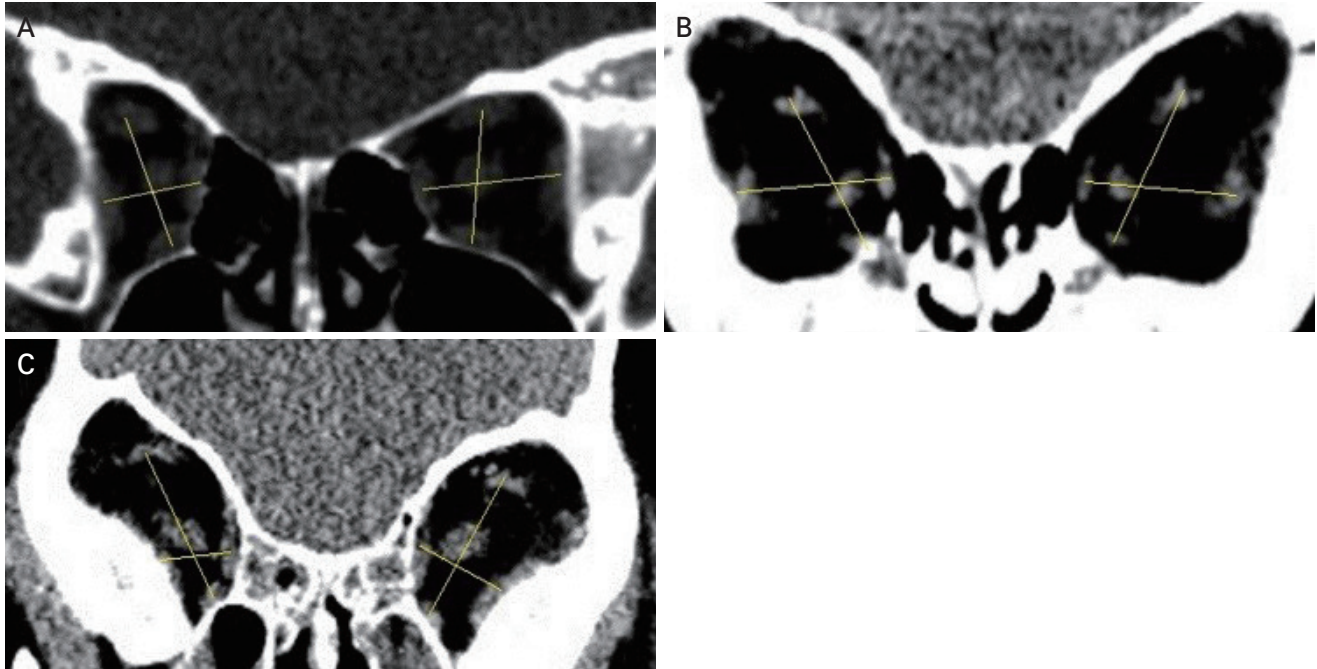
Coronal orbital computed tomography scans. (A) In mild V-pattern subjects, the orbital walls surround typically oriented four rectus muscles. (B) In moderate subjects, medial bowing of sphenoid greater wing leads to the lateral rectus down. (C) In severe V-pattern subjects, the shorter and wider orbits was accompanied by lateral displacement of the superior rectus muscles. Horizontal lines joining the center of the belly of the horizontal rectus muscles and vertical lines joining the center of the belly of the vertical rectus muscles.
